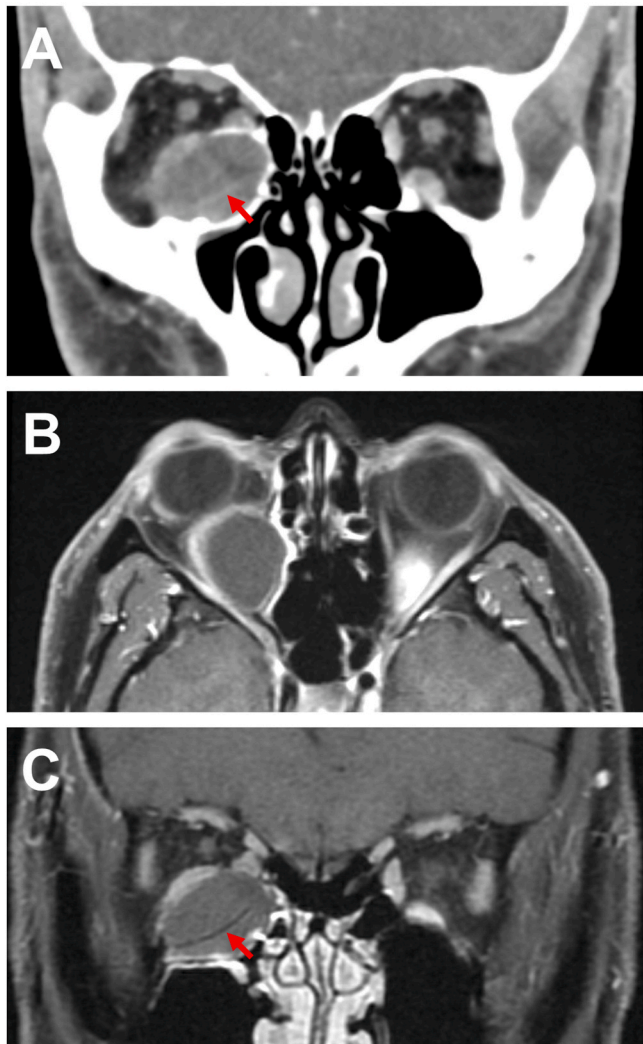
(A) Orbital CT image demonstrating a giant, well-circumscribed cystic mass in the inferior right orbit abutting and displacing the inferior and medial rectus muscles. (B, C) Orbital MRI demonstrating a non-enhancing well-circumscribed mass abutting the globe and inducing proptosis, with linear heterogeneity seen within the mass (red arrow). A curvilinear hypodensity within the cystic mass (red arrows).
